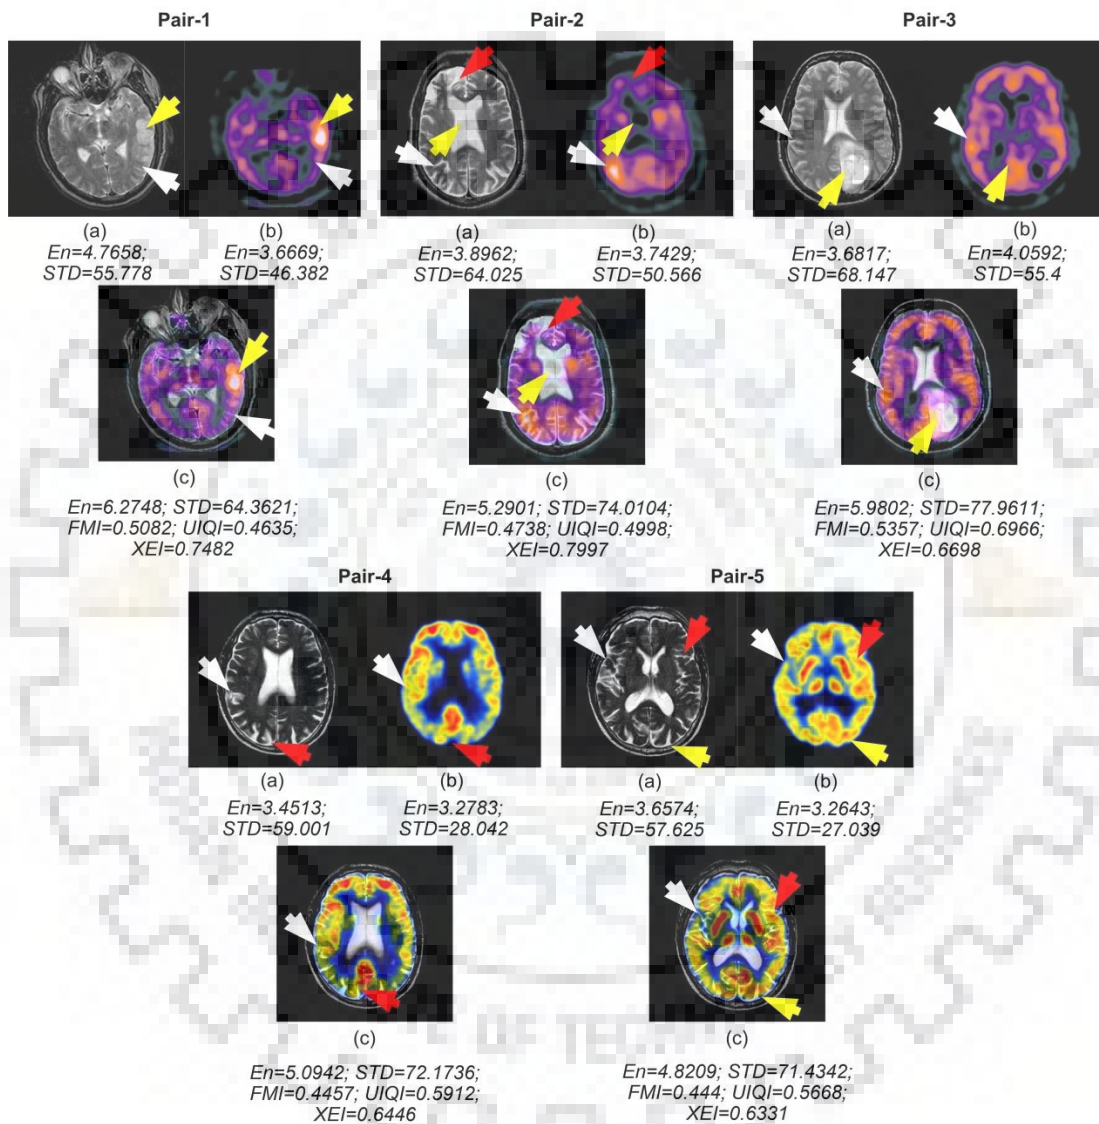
Fused images using the proposed method on various test neurological images along with quantitative metrics. Pair-1, 2 and 3 Input image (a) MR image (b) SPECT image (c) Fused image, Pair-4 and 5 Input image (a) MR image (b) PET image (c) Fused image
